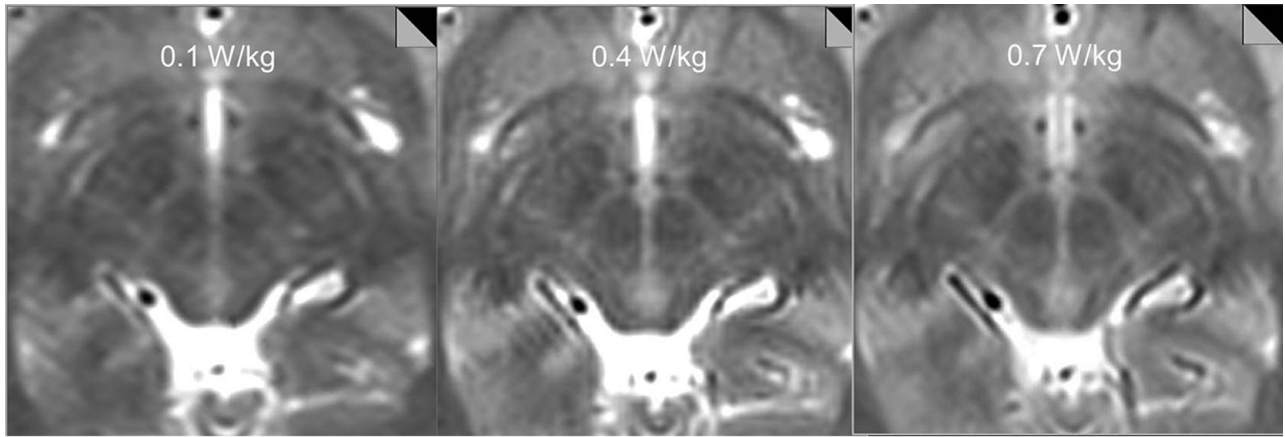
Tests on a volunteer subject show decreasing anatomic detail of the subthalamic region with decreasing SAR. T2-weighted images obtained with an SAR = 0.1 W/kg and 0.4 W/kg were deemed insufficient for stereotaxis by consensus view between the neuromodulation neurosurgeon and neuroradiologist, while images obtained with an SAR of 0.7 W/kg were adequate for intraoperative stereotaxis.
